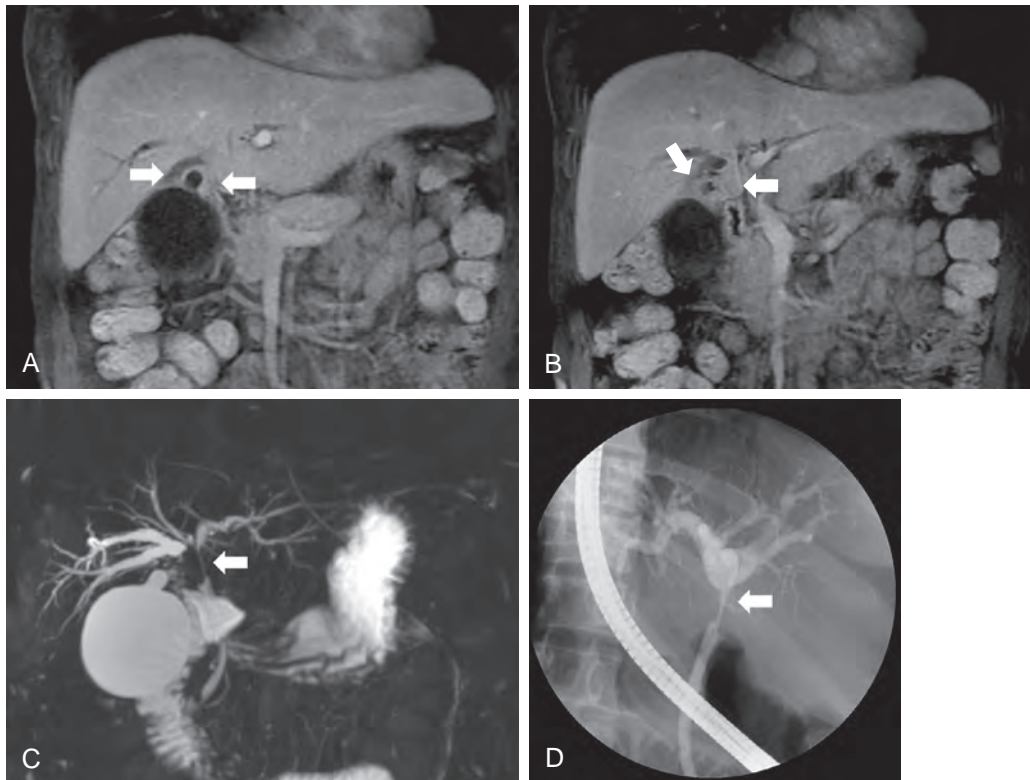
Gallbladder carcinoma with direct spread to the bile duct. A and B. Coronal MR images demonstrate an enhancing gallbladder carcinoma with involvement of adjacent bile duct (arrows). C. MRCP maximum intensity projection image demonstrates a malignant stricture involving the common hepatic duct as well as narrowing of the lumen at neck portion of the gallbladder (arrow). D. Direct cholangiography also demonstrates the stricture (arrow) involving the confluence of the right and left hepatic ducts (hilum of the bile duct), with dilation of the intrahepatic bile ducts.
